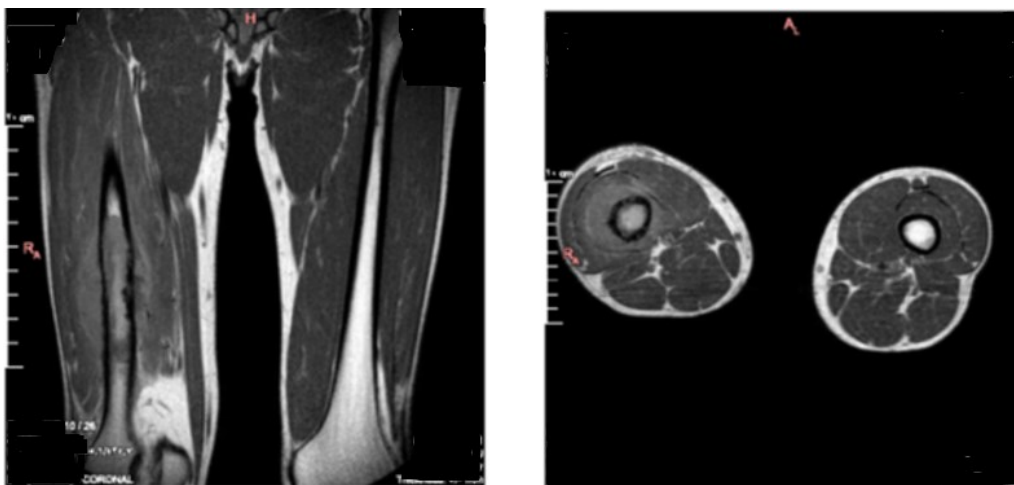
Preoperative MRI of the right femur.
